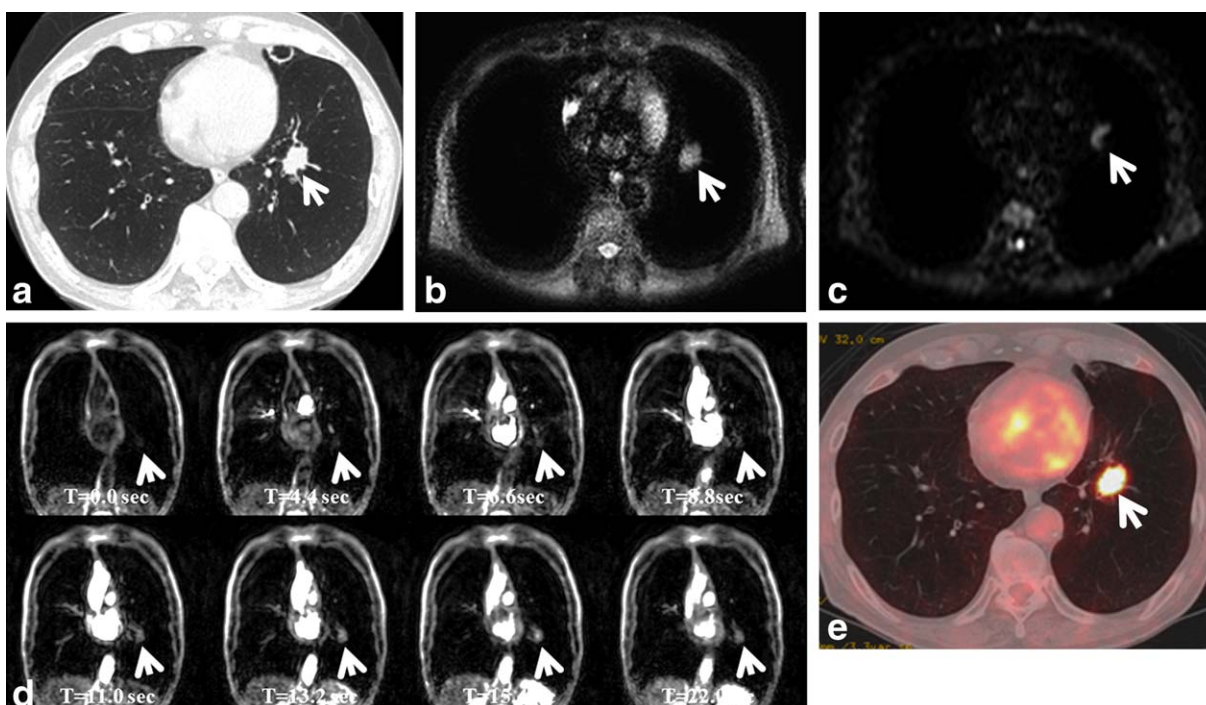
MRI depiction of lung adenocarcinoma in a 75-year-old man. A: Lung window image of thin-section (1.5-mm section thickness) CT scan obtained at ventricular level shows a nodule of 18 mm in diameter (arrow) in the left lower lobe with pulmonary emphysema in both lungs. B: STIR turbo spin-echo imaging shows a high-intensity nodule (arrow) in the left lung. C: Diffusion-weighted MR image manifests the nodule (arrow) as high-signal intensity lesion, suggesting a malignant one. D: Dynamic MRI with ultrafast-gradient-echo technique (left to right: upper line, $t = 0.0$ sec; $t = 4.4$ sec; $t = 6.6$ sec; and lower line, $t = 11.0$ sec; $t = 13.2$ sec; $t = 15.4$ sec, and $t = 22.0$ sec) shows a well-enhancing nodule (arrow) in the left lower lung zone, and heterogeneous enhancement in both lungs due to pulmonary emphysema. The nodule exhibits high enhancement in the systemic circulation phase ($t = 11.0$ – 22.0 sec) owing to high blood supply from systemic circulation. This nodule was assessed as a malignant lesion on dynamic contrast-enhanced MRI. E: PET/CT demonstrates high FDG-uptakes within the nodule (arrow).
